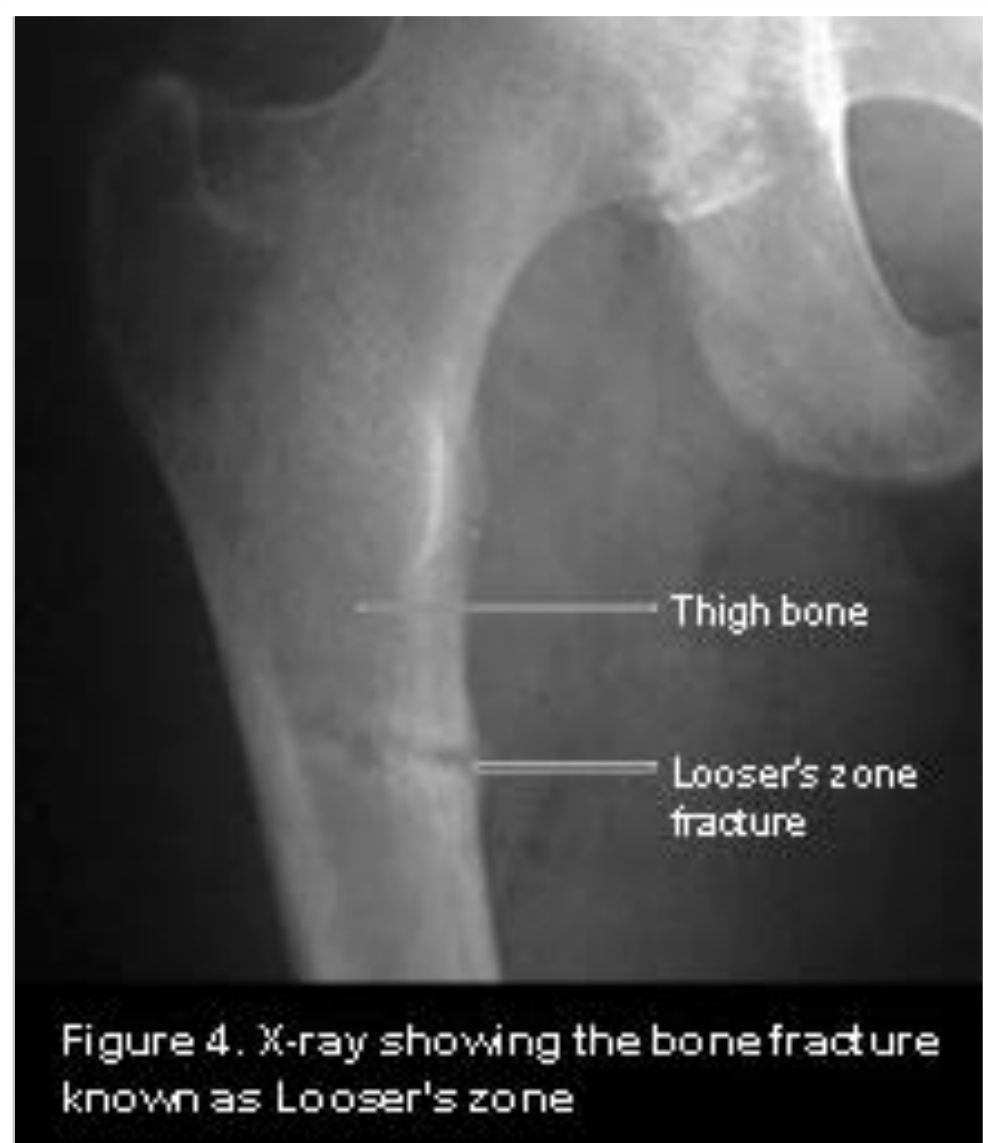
X-ray showing the bone fracture known as Looser's zone
